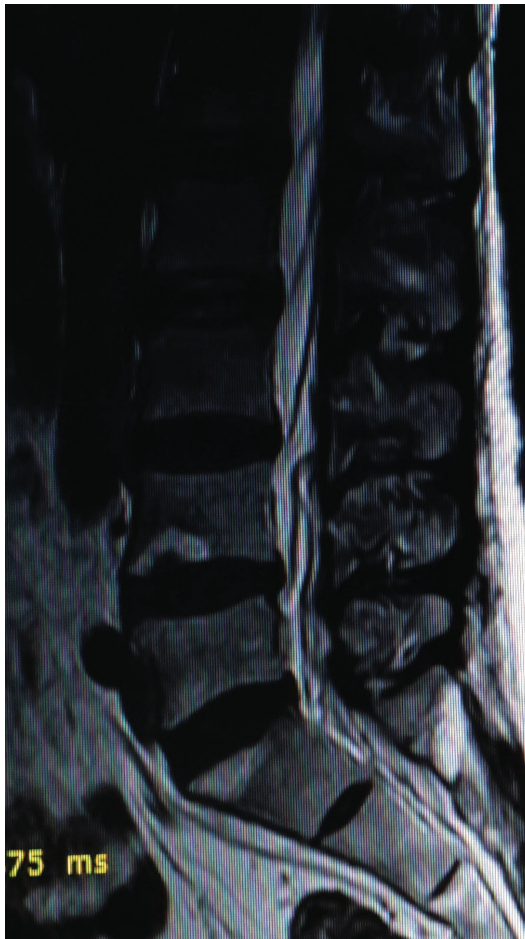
Sagittal T2-weighted second round MRI showed almost complete regression of the herniated nucleus pulposus at the L4-5 level (her complaints were resolved 12 weeks later)
